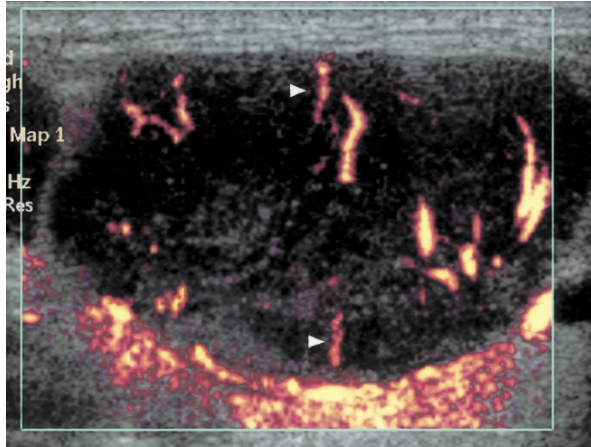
Power Doppler sonogram of a malignant node with peripheral vascularity (arrowheads).
